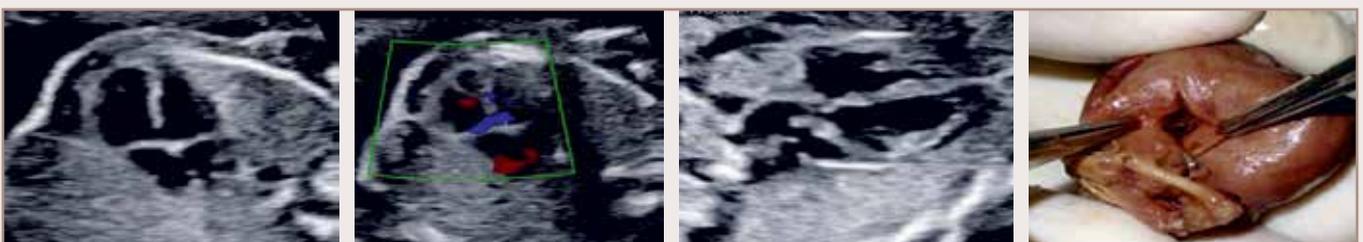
Antenatal Sonography Shows VSD In 2d and Colour Four Chamber Views and Thick Aortic Valvein LVOT View /autopsy Shows Bicuspid Aortic Valve
